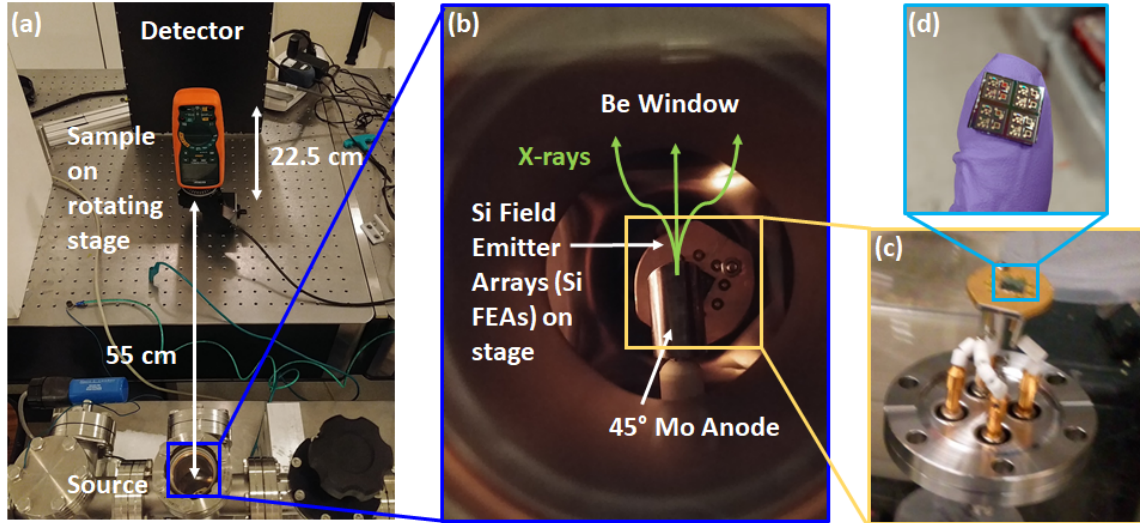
(a) Photograph of the x-ray test setup with a multimeter as the test sample which sits on a rotating stage. The source is approximately 55 and 77.5 cm from the sample and detector, respectively. The x-ray source (b) is a bremsstrahlung source housed in a small vacuum chamber with a small ion and turbo pump with a Si field emitter arrays (Si FEAs) as the electron source and a molybdenum anode biased at high voltage; the x-rays travel out towards the sample through a Be window. The base pressure of the system is roughly  $10^{-8}$  Torr and operates at roughly  $10^{-7}$  Torr when active. The (c) electron source is a (d) Si FEA chip containing (Die size:  $7 \times 7$  mm<sup>2</sup>) and three wire-bonded devices. The cathode or substrate of the Si FEA chip is mounted to feedthrough using silver paint and wire-bonds are used to connect the gates to individual feedthroughs
